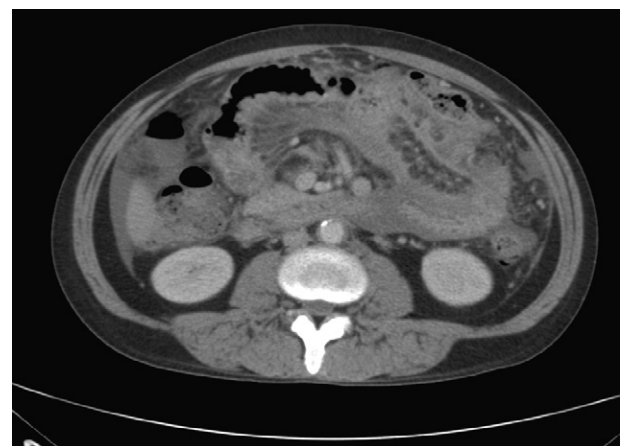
Computed tomography of the abdomen after administration of contrast medium showing thickened bowel wall and mesentery in an AIDS patient with *Mycobacterium avium* complex peritonitis.
